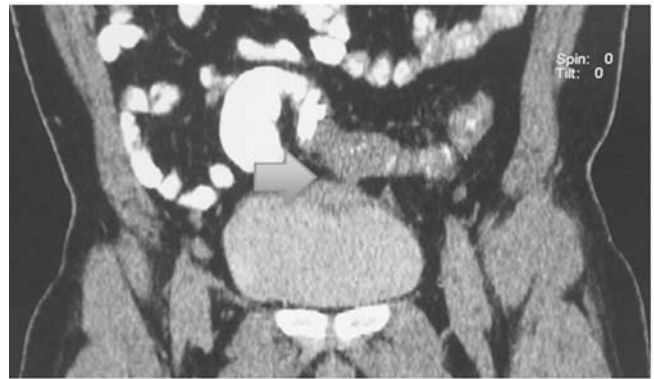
Coronal view of the whole abdominal CT scan with oral contrast of the patient which shows a fistulous connection (arrow) between the sigmoid colon and the superior portion of the bladder. The bladder also shows enhancement due to the mixture of dye and urine.
